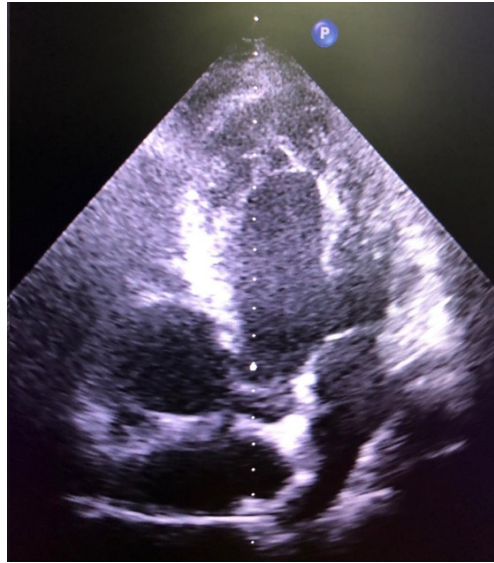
Echocardiographic imaging of noncompaction cardiomyopathy- Four chamber view.
